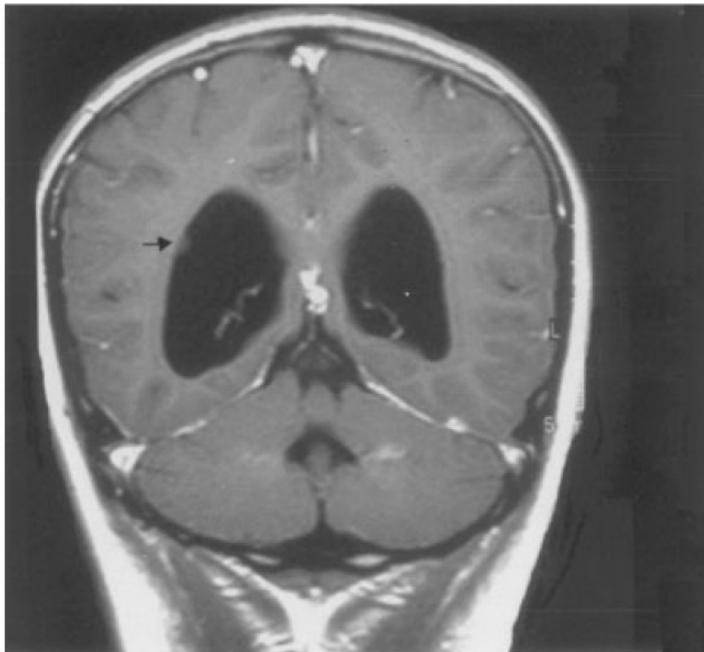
Patient 4. A: A three-dimensional CT scan reconstruction of the skull showing a discontinuity at the midline of the occipital bone. B: T1-weighted MRI (coronal section) showing nodular, subependymal heterotopia on the right side (arrow).
